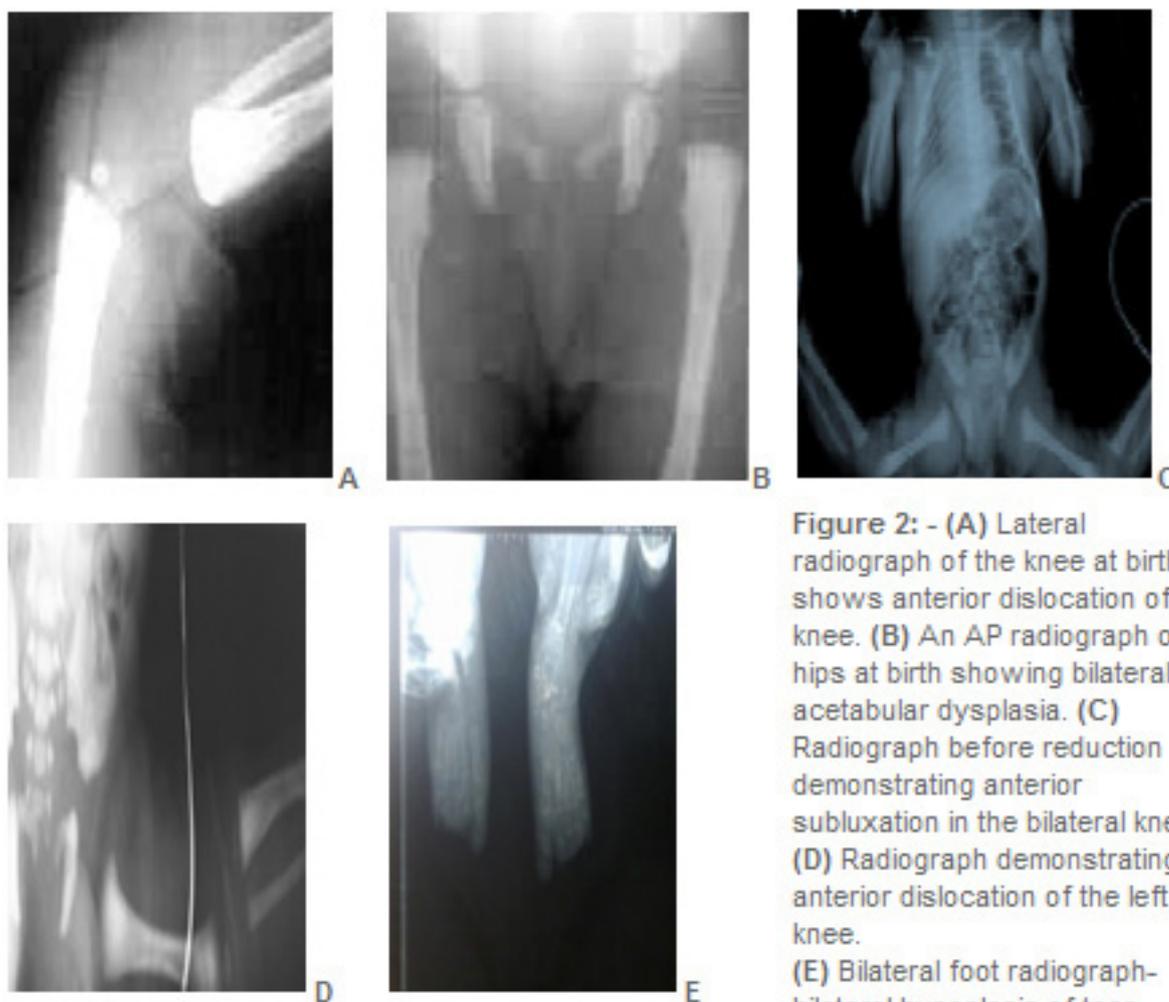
(A) Lateral radiograph of the knee at birth shows anterior dislocation of the knee. (B) An AP radiograph of hips at birth showing bilateral acetabular dysplasia. (C) Radiograph before reduction demonstrating anterior subluxation in the bilateral knees. (D) Radiograph demonstrating anterior dislocation of the left knee. (E) Bilateral foot radiograph- bilateral hypoplasia of toes.
